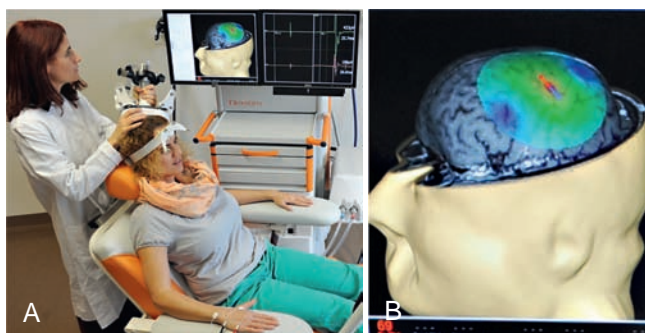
E-field navigated transcranial magnetic stimulation (nTMS) motor. (A) nTMS examination. The position of the patient's head and the transcranial magnetic stimulation (TMS) coil in space is continuously determined by a camera (not shown) using the reflectors fixed to the coil and head. The TMS coil is guided freehand during the examination. The position of the coil in relation to the patient's head (MRI three-dimensional reconstruction) is visualized on the left screen in real time. Stimulation pulses are triggered by the examiner using a foot pedal (not shown). If the stimulation hits a motor area, the stimulation effect is recorded by electromyographic electrodes (surface electrodes; here, patient's left hand), and the resulting muscle action potential is displayed and recorded on the right screen. (B) Detail enlargement of the left screen. The red and blue arrow shows the direction of the biphasic electric field induced by the magnetic pulse. A bright arrow indicates optimal coil tilting with maximal e-field induction in the underlying cortex. The central red area corresponds to the cortex area, which is stimulated with suprathreshold intensity. In the green and blue areas, the exponentially decreasing electric field no longer has an excitatory effect.
